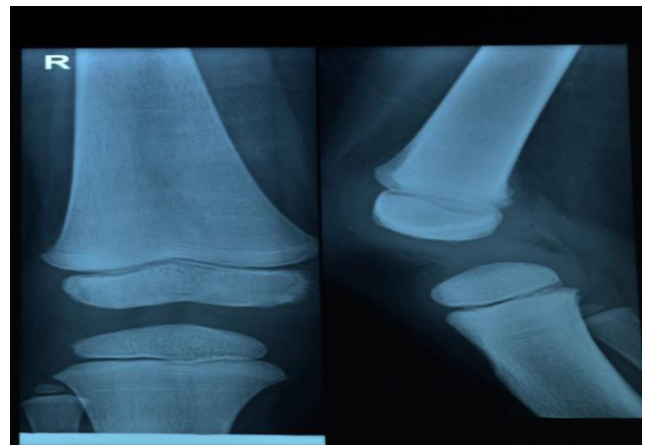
X-ray lower limb showing coarsened trabeculae, loss of density, diffuse osteoporosis and growth arrest lines.
